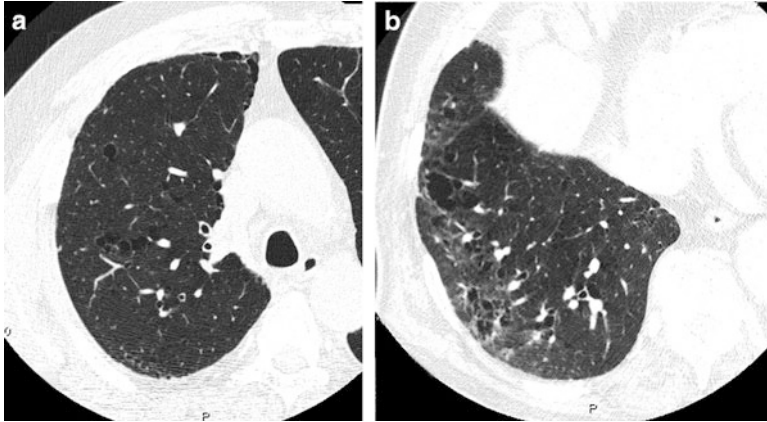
Combined pulmonary fibrosis and emphysema (CPFE). (a) High-resolution computed tomography (HRCT) at the upper lung shows centrilobular emphysema. (b) HRCT at the lower lung shows centrilobular cysts surrounded by reticular and ground-glass opacity, a pattern definitely different from that of usual interstitial pneumonia (UIP)
